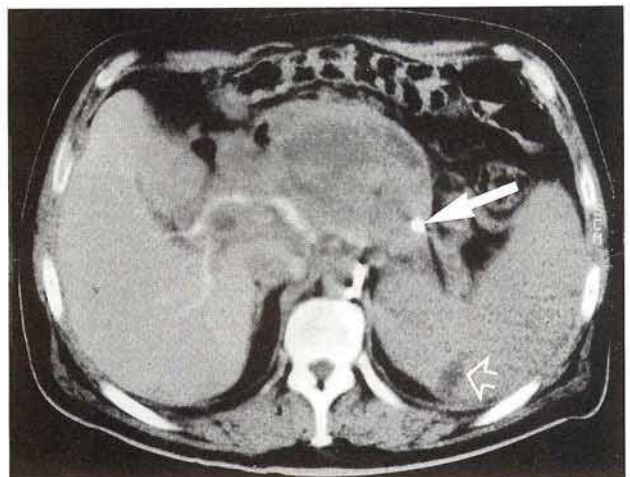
CT following splenic artery embolization with a spiral (closed arrow), leading to cessation of bleeding. The open arrow indicates splenic infarction.
